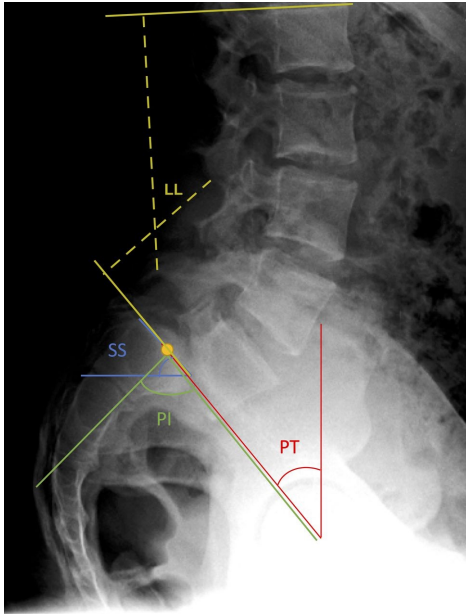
Lumbar lordosis (LL) — lateral radiograph with LL, SS, PI, PT annotated.
